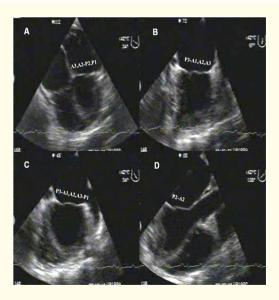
Basic 2D transesophageal echocardiographic views for the assessment of mitral valve apparatus, in the mid-esophageal position Segments of the anterior leaflet (A1, A2, and A3) and posterior leaflet (P1, P2, and P3) are visualized and labeled in corresponding views. A parasternal long axis; B - two-chamber; C - mitral commissural; D -three-chamber view.
